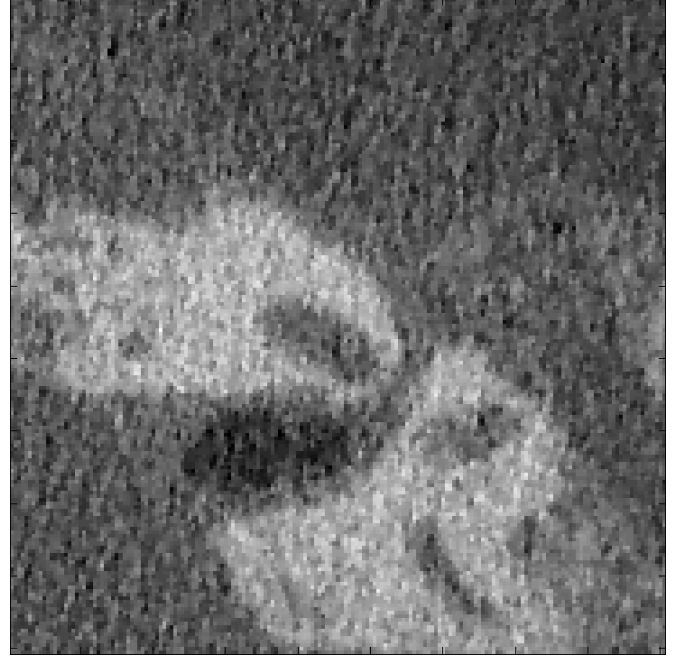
Standard CT image of the head zoomed in on inner-ear anatomy.
